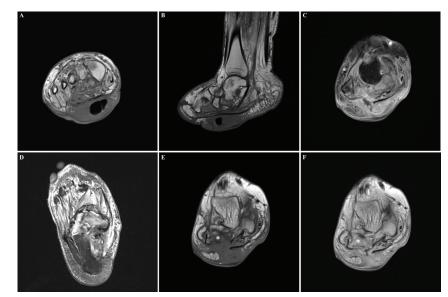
MRI. A: T1 weighted, turbo spin echo sequence (TSE) coronal view and B: sagittal views. Low signal intensity areas in the plantar soft tissue with swelling and a plantar gas collection showing inflammation and abscess. C: T1 weighted, TSE, fat suppression (FS) post-gadolinium contrast coronal view. High signal intensity area corresponding with the low inflammation and plantar abscess in A and B. D: Proton density (PD) weighted, FS, transversal view. Extensive high signal intensity areas in the soft tissues and navicular, cuneiform and cuboid bones representing oedema. E: T1 weighted, TSE, pre-gadolinium contrast coronal view and F: and post-gadolinium contrast coronal view. Extensive low signal intensity areas in soft tissues and the cuboid bone (marked with*) on E corresponding with high signal intensity on F representing gadolinium uptake in the corresponding oedematous soft tissues and osseous structures described in D, suggesting osteomyelitis and soft tissue inflammation.
